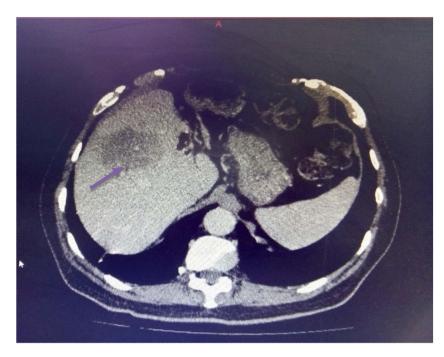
Abdominal CT scan shows a centrolobular hypodense multilocular lesion (arrow).
